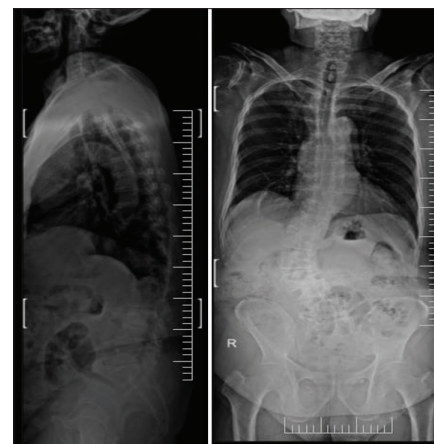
Preoperative lateral and anteroposterior whole spine X-rays of patient 2 showing degenerative scoliosis.
